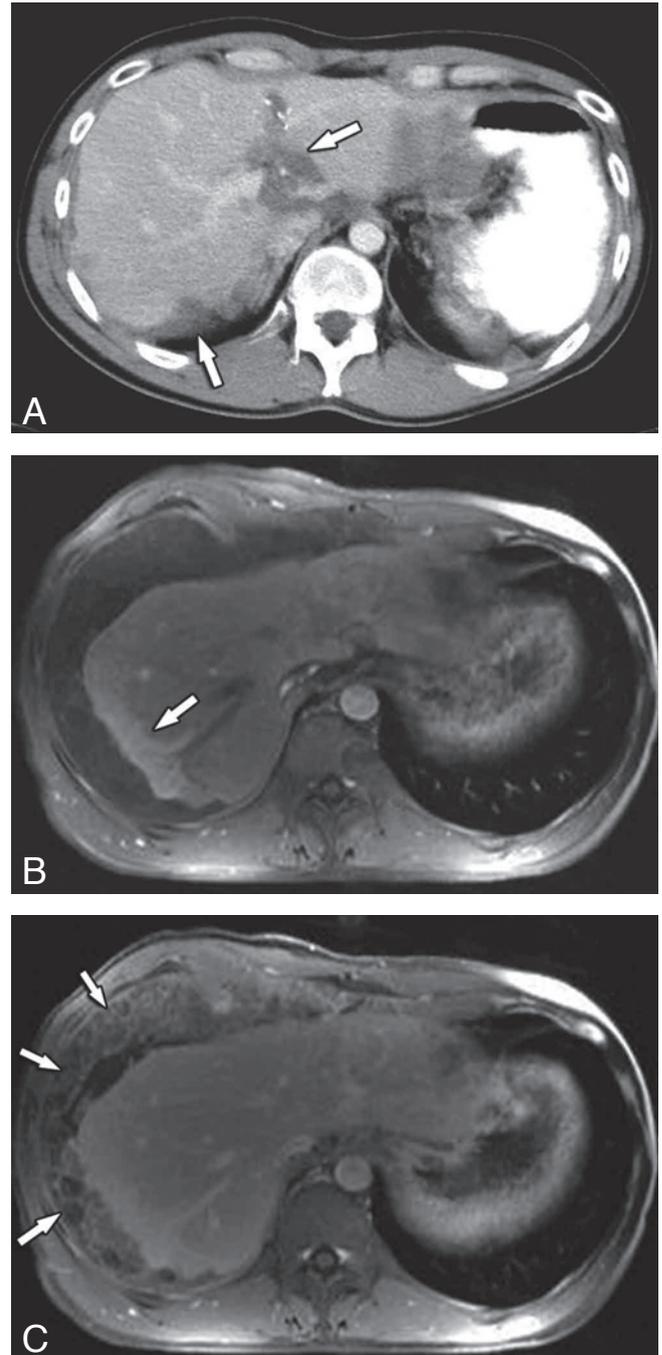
Axial contrast-enhanced CT scan (A) and MR GRE T1 +Gd early (B) and delayed (C) phase from a 40-year-old male with pseudomyxoma peritonei: scalloping of the liver with secondary perfusion defects and calcified implants at the falciform ligament.
